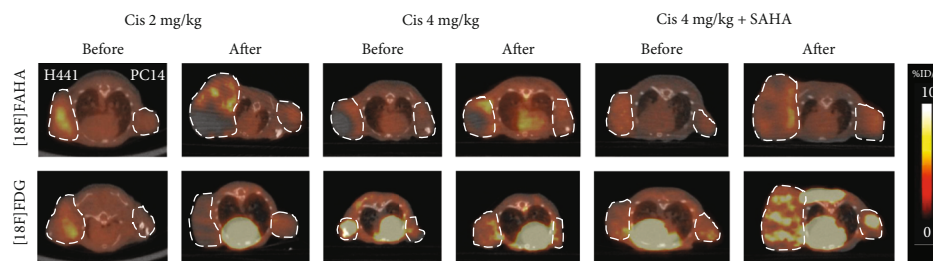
Axial tumor $[^{18}\text{F}]$ FAHA (upper panel) and $[^{18}\text{F}]$ FDG (lower panel) imaging before and after drug administration. $[^{18}\text{F}]$ FAHA PET/CT images were summed over 10 min (20–30 min after $[^{18}\text{F}]$ FAHA injection). Cisplatin significantly increased $[^{18}\text{F}]$ FAHA radioactivity in H441 and PC14 xenograft tumors, and this effect was blocked by SAHA. $[^{18}\text{F}]$ FDG imaging at 45–55 min after injection. Tumor $[^{18}\text{F}]$ FDG accumulation decreased after administration of cisplatin, but increased after administration of cisplatin with SAHA.
